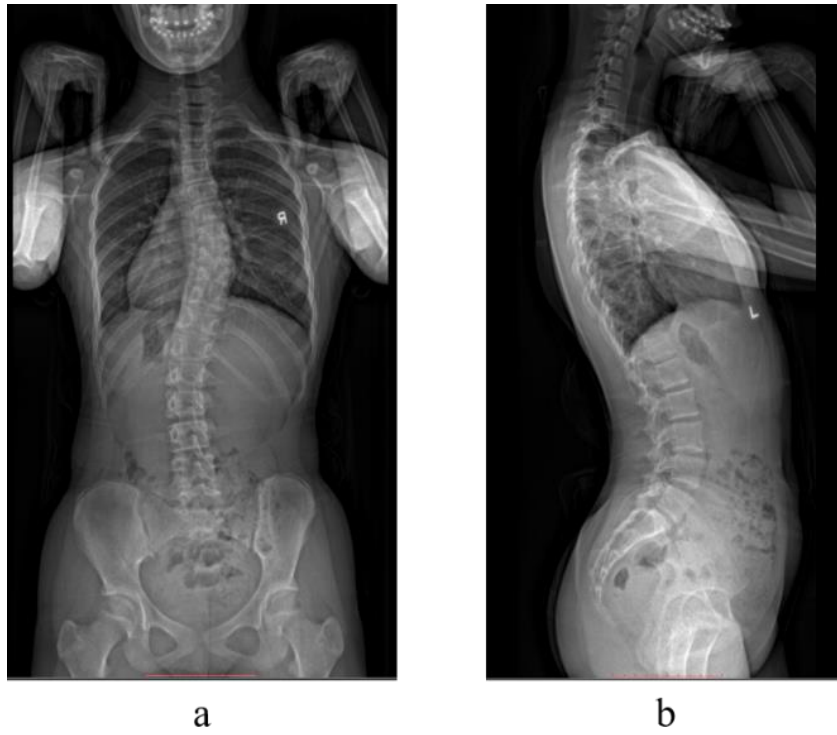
Radiographic images of Subject 18003: (a) frontal plane and (b) sagittal plane
